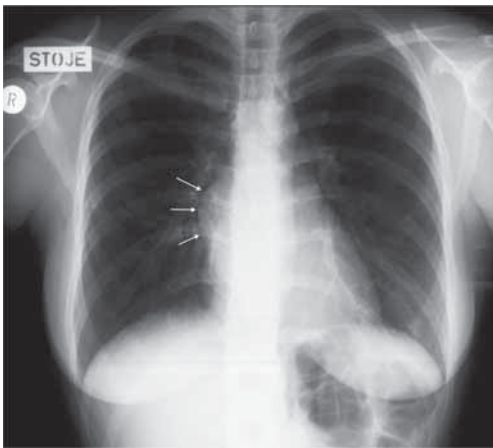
Chest X-ray showed a homogenous, well delineated, half-circular bulge of right mediastinum at the level of the left atrium.
